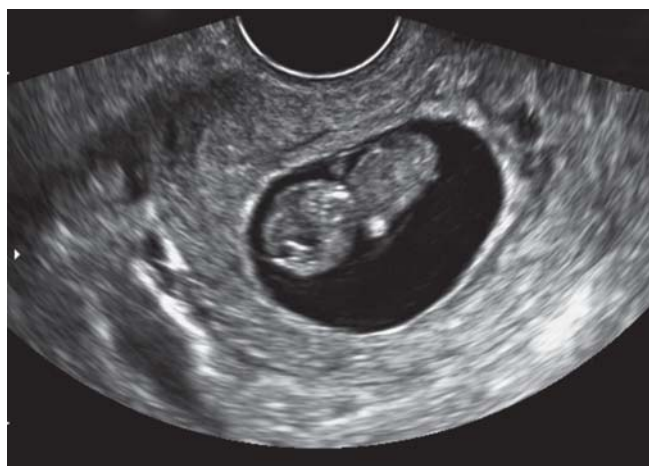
Transvaginal ultrasonography showing ongoing viable intrauterine pregnancy
